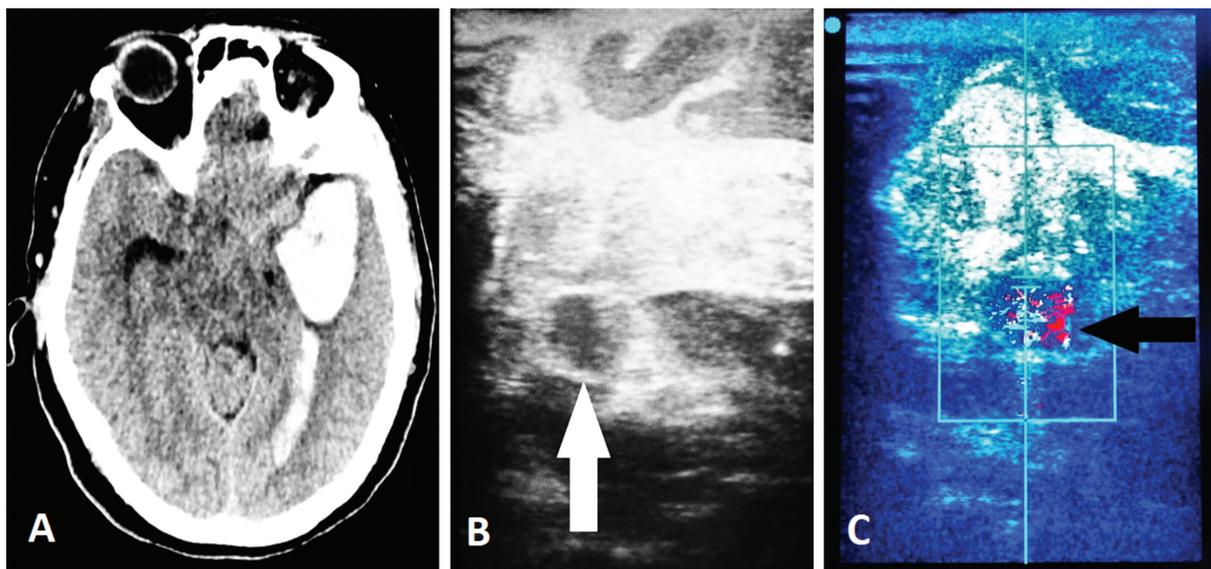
(A) Preoperative CT scan showing left temporal intracerebral hematoma associated with subarachnoid hemorrhage and intraventricular hemorrhage suggesting aneurysmal rupture. (B) The IOUS showing the hyperechoic intracerebral hematoma associated with a circular image with a hyperechoic wall and hypoechoic content suggestive of aneurysm (white arrow). (C) The IOUS with color Doppler showing swirling flow inside the circular lesion, confirming the diagnosis of aneurysm (black arrow).
